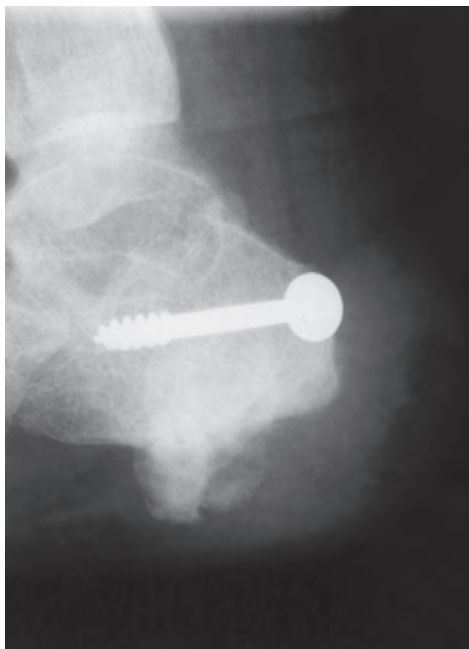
Lateral radiograph of left foot after calcaneal osteotomy with internal fixation. Note osseous changes to plantar surface of the osteotomy site.
